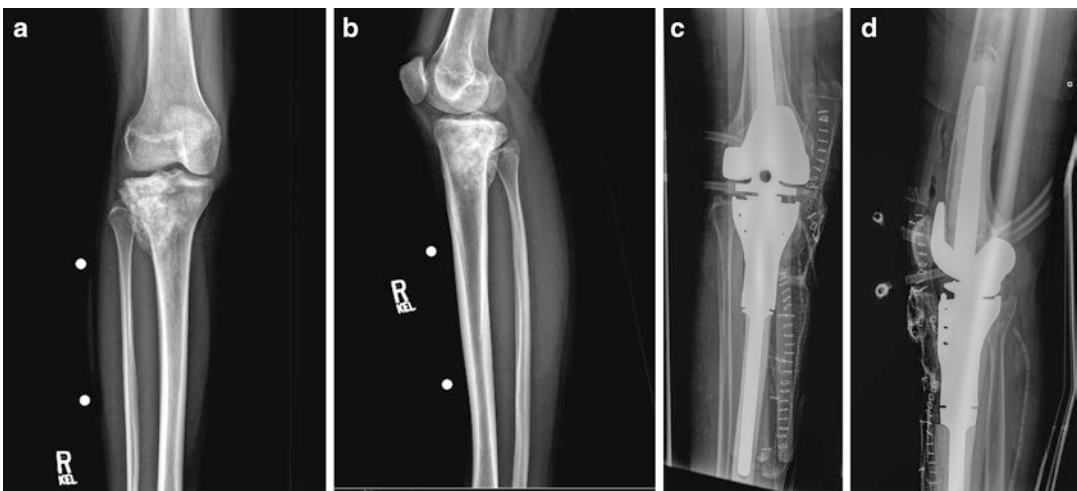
AP and lateral radiographs reveal osteolytic and osteoblastic lesion in the right proximal tibia (a, b). Postoperative AP and lateral radiographs show the resection and reconstruction with a megaprosthesis (c, d)
